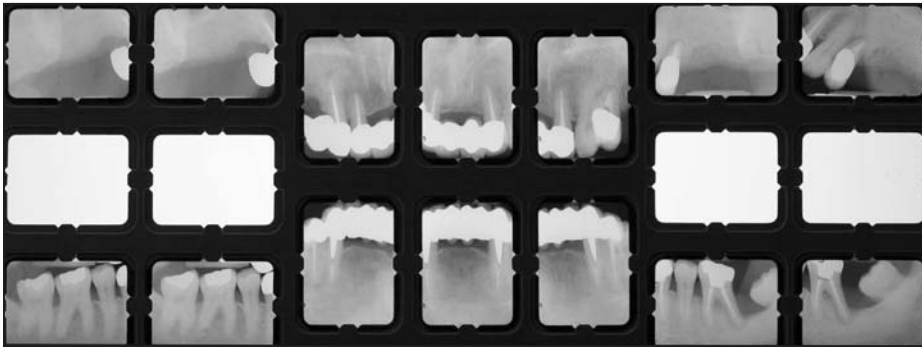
Preoperative periapical radiograph exhibiting multiple missing teeth, multiple root canal therapy with posts, multiple fixed partial dentures with a distal cantilever on No. 5, extruded molars on teeth Nos. 30 and 31, endodontically treated tooth No. 12 with periapical radiolucency, endodontically treated tooth No. 19 with localized vertical defect on the distal with radiographic furcation involvement and severely mesially tilted third molar tooth No. 17.
